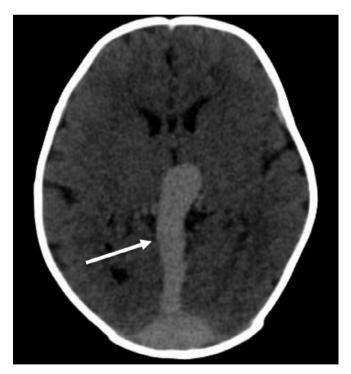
Plain and contrast-enhanced view of a brain CT scan for Case 1, revealing the dilated vein of Galen (white arrow).
